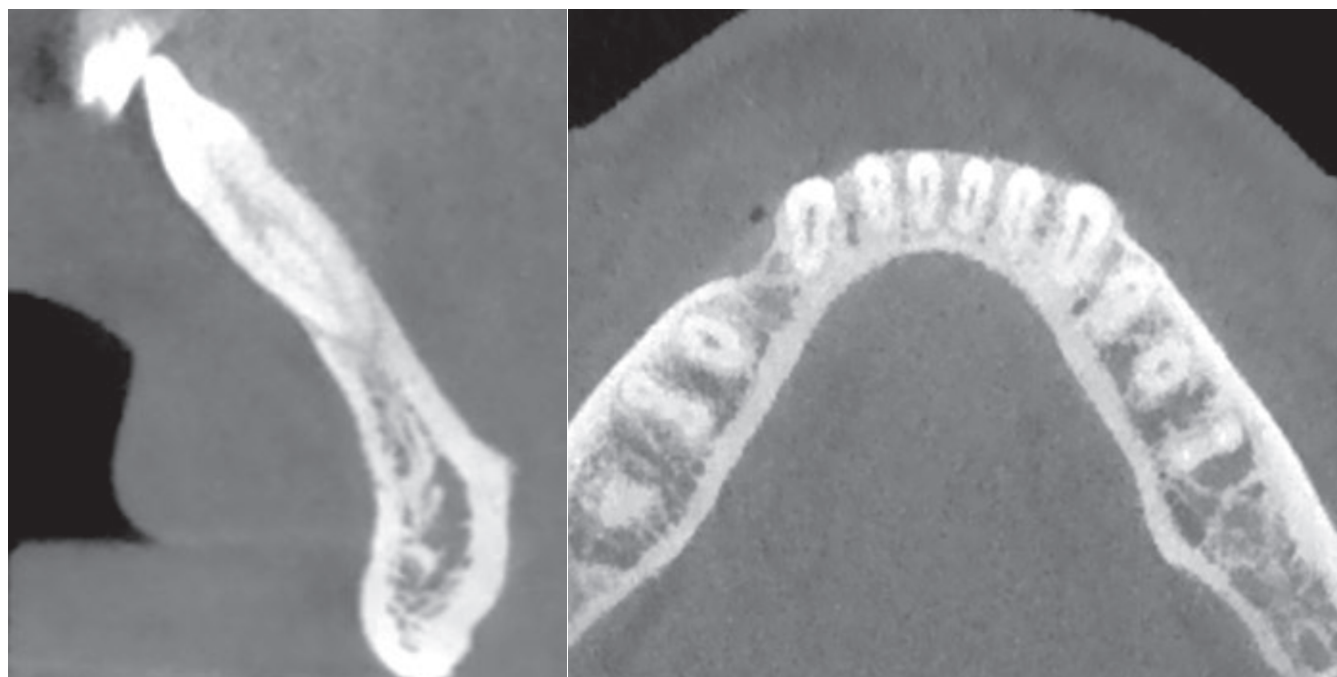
Figure showing Type III canal configuration in lateral incisor using CBCT
